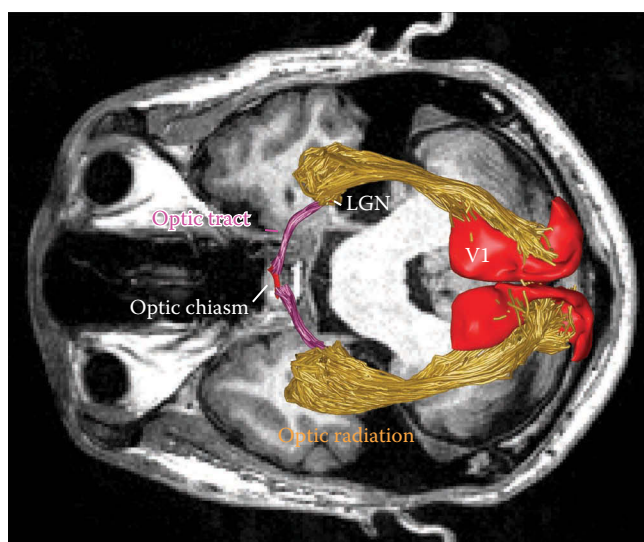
Genucostriate pathway. The primary pathway by which the eye sends signals to the cortex is the geniculostriate pathway, consisting of the optic nerve/optic tract, the lateral geniculate nucleus, and the optic radiation. The image shows a computerized rendering of the optic tract (purple) and optic radiation (yellow), identified by fiber tractography and diffusion imaging of a living human brain. The underlay is an axial slice acquired from a T1-weighted magnetic resonance image. Image by Shumpei Ogawa.
